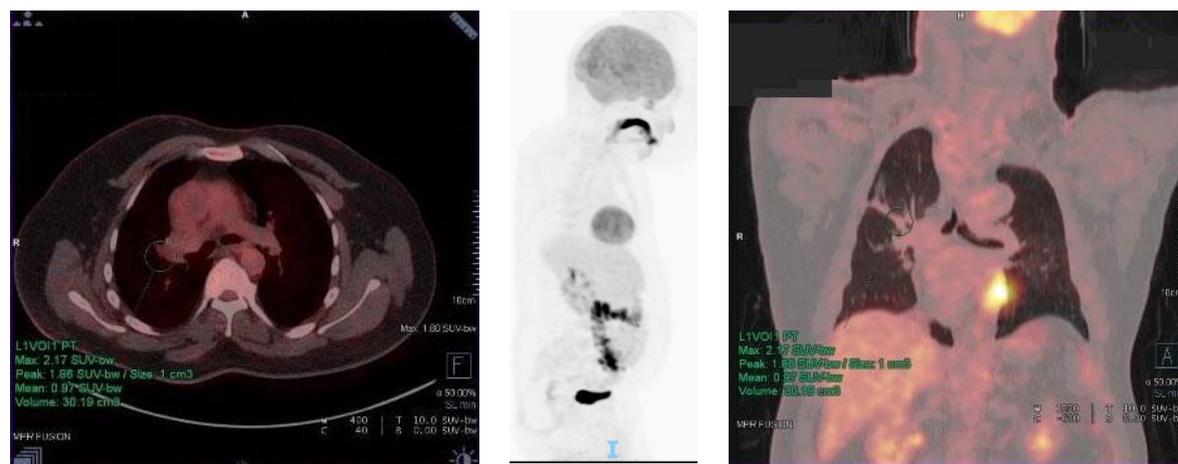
Initial <sup>18</sup>F-FDG PET/CT scan and MIP images
